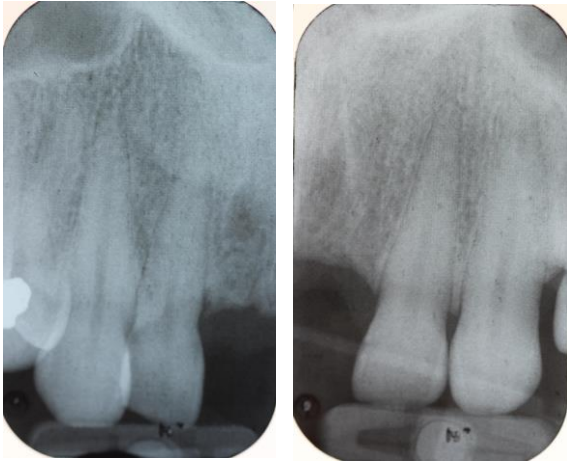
(Left) and 2.2 (Right) Intra-oral periapical radiographs of UR3,2 and UL2,3
